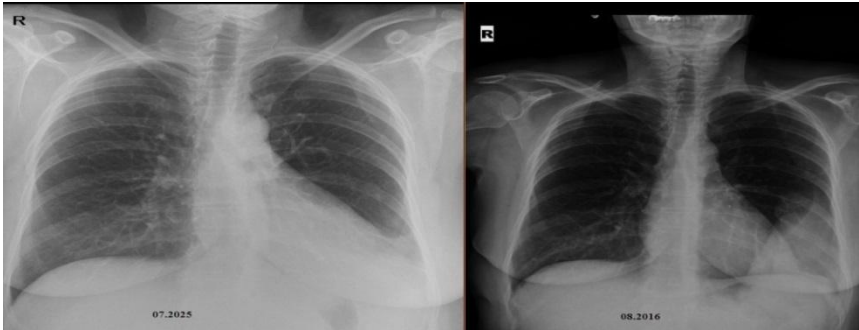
Preoperative and postoperative Thorax CT
